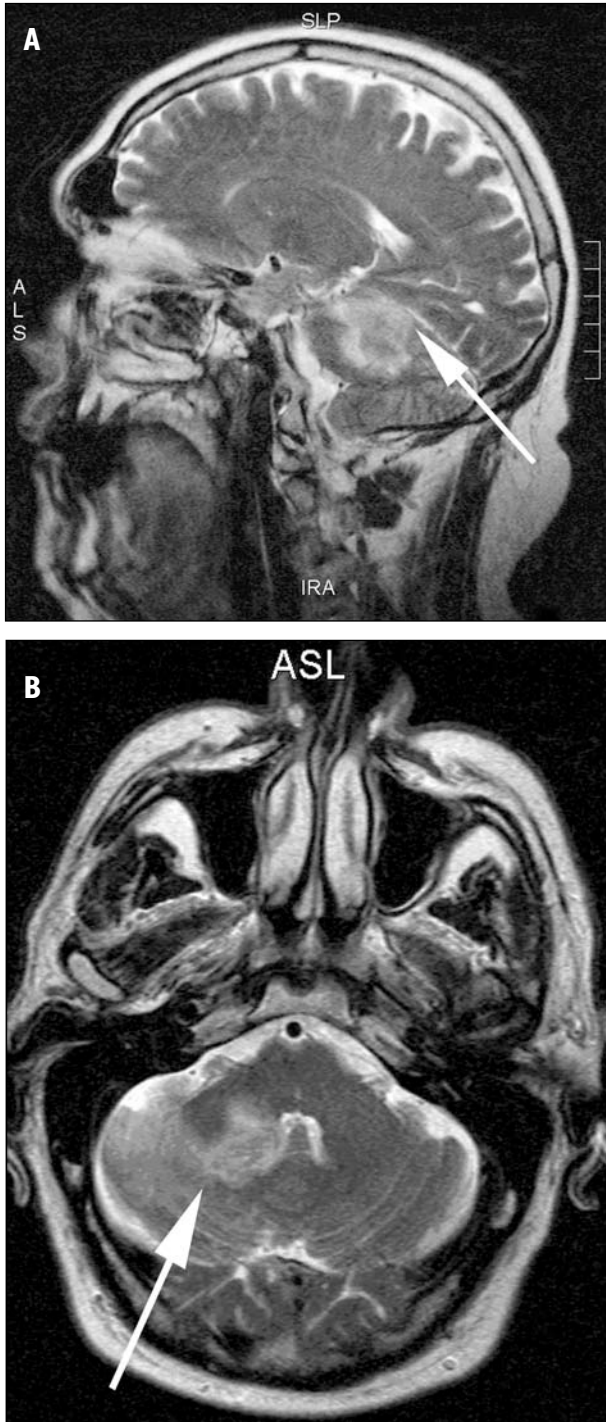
Magnetic resonance imaging scans from a 53-year-old man presenting with a cerebellar stroke, whose symptoms included a horizontal and vertical nystagmus, right-sided Horner's syndrome, vertical diplopia, mild dysarthria and right-sided discoordination. The CT scan showed infarction of the right cerebellum and adjacent midbrain. Scans A and B show extensive acute right cerebellar infarction extending into the midbrain. Scan A shows the involvement of the right superior cerebellar artery, and scan B the anterior inferior cerebellar artery. Subsequent MRA of the circle of Willis and neck vessels showed right superior cerebellar and possibly right posterior cerebral arterial involvement. There were also right supratentorial lacunar infarcts, but no stenosis of carotid or vertebral arteries.
